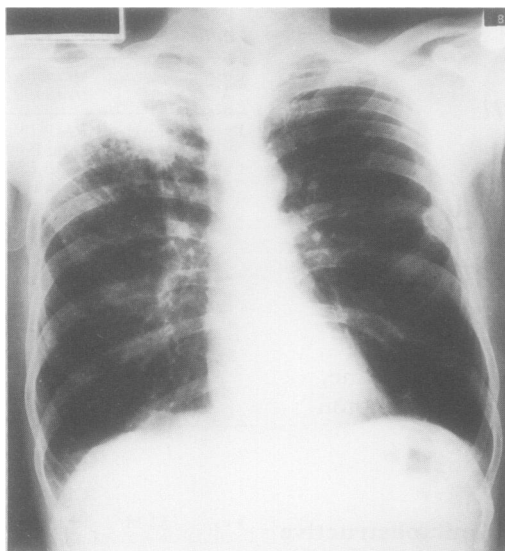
Chest radiograph of case 3 at presentation in June 1991.
